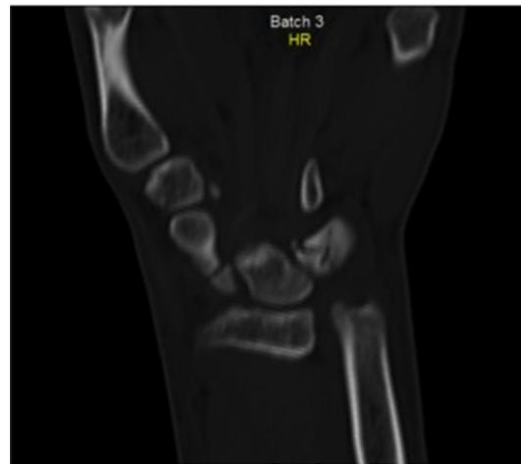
CT view of scaphoid fracture
